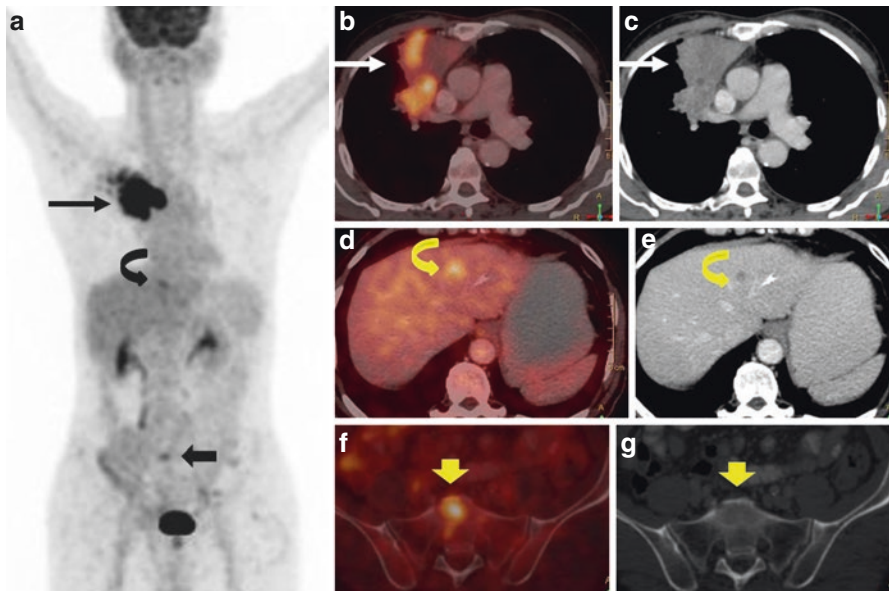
FDG PET/CT MIP (a) and axial images show a large area of FDG-avid consolidation in the right upper lobe (maxSUV 12.93) (b, c). FDG-avid hypodense lesion is noted in the left lobe of the liver (curved arrow in d, e) and a marrow lesion in the sacrum (block arrow in f, g). Biopsy of all the lesions showed granulomatous inflammation with epithelioid granulomas and multinucleated Langhans and foreign body giant cells, consistent with tuberculosis
